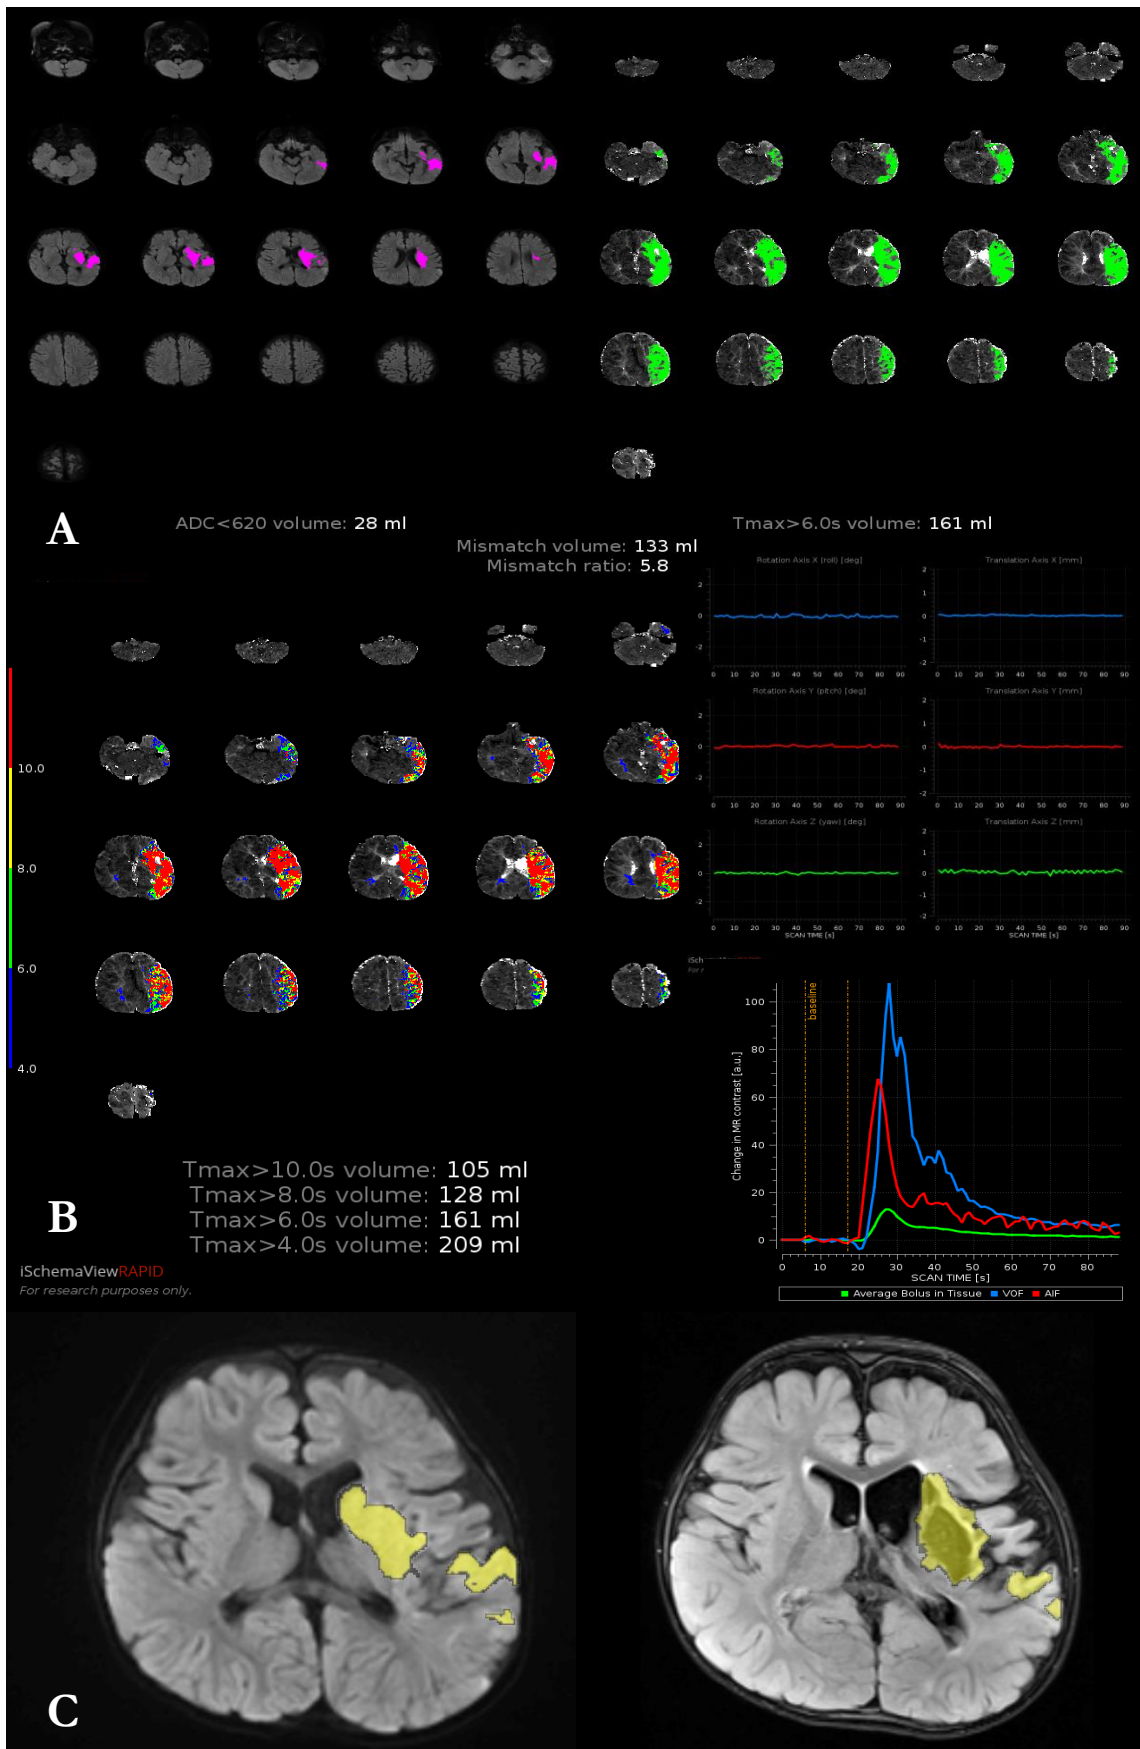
RAPID output and manual segmentation Case study 6 - (A) Automated mismatch segmentation core (left) hypoperfusion (right) using standard RAPID thresholds (B) Alternate  $T_{\max}$  thresholds, head motion, and AIF curves. (C) Manual segmentation of acute DWI lesion 18.1mls (left) and chronic T2 FLAIR lesion 25.4mls (right)
